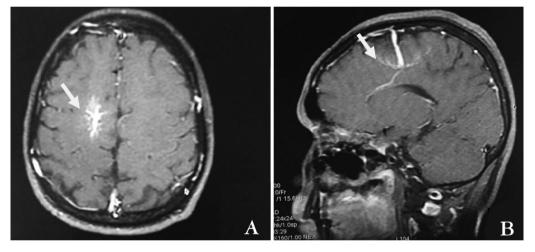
Gadolinium enhanced magnetic resonance imaging showing a lesion (caput medusae) in the frontoparietal region in A arrow and dilated draining vein in B arrow
